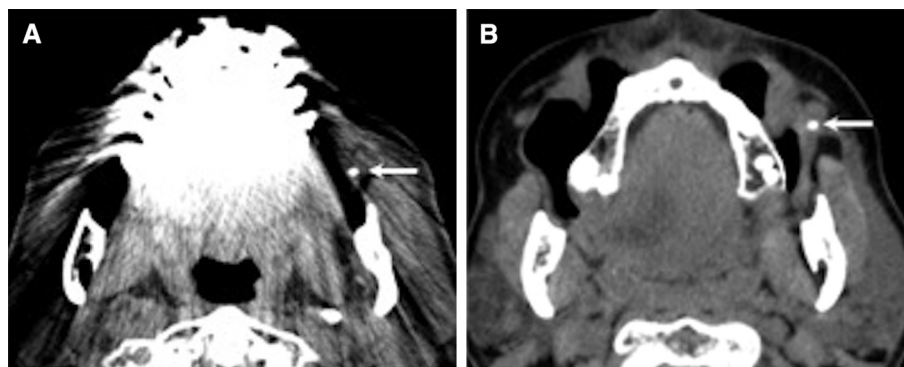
Contrast-enhanced computed tomography images of a 36-year-old man with episodes of painful left parotid swelling associated with eating. (A) A small sialolith (arrow) can be identified at the level of the left distal parotid duct. (B) After a repeated scan with the head in hyperflexion and with puffed cheeks, the sialolith (arrow) can now be visualized much more clearly; artifacts related to dental restoration materials are eliminated, and the distance to the ductal orifice can be measured as well.
